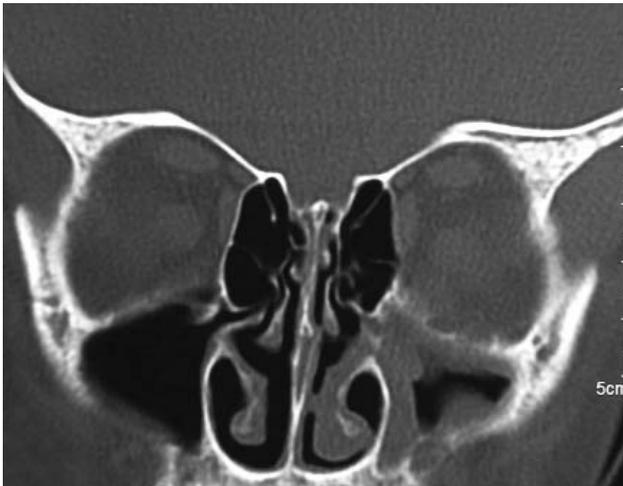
Postoperative control CT scan demonstrating restoration of the orbital floor.
